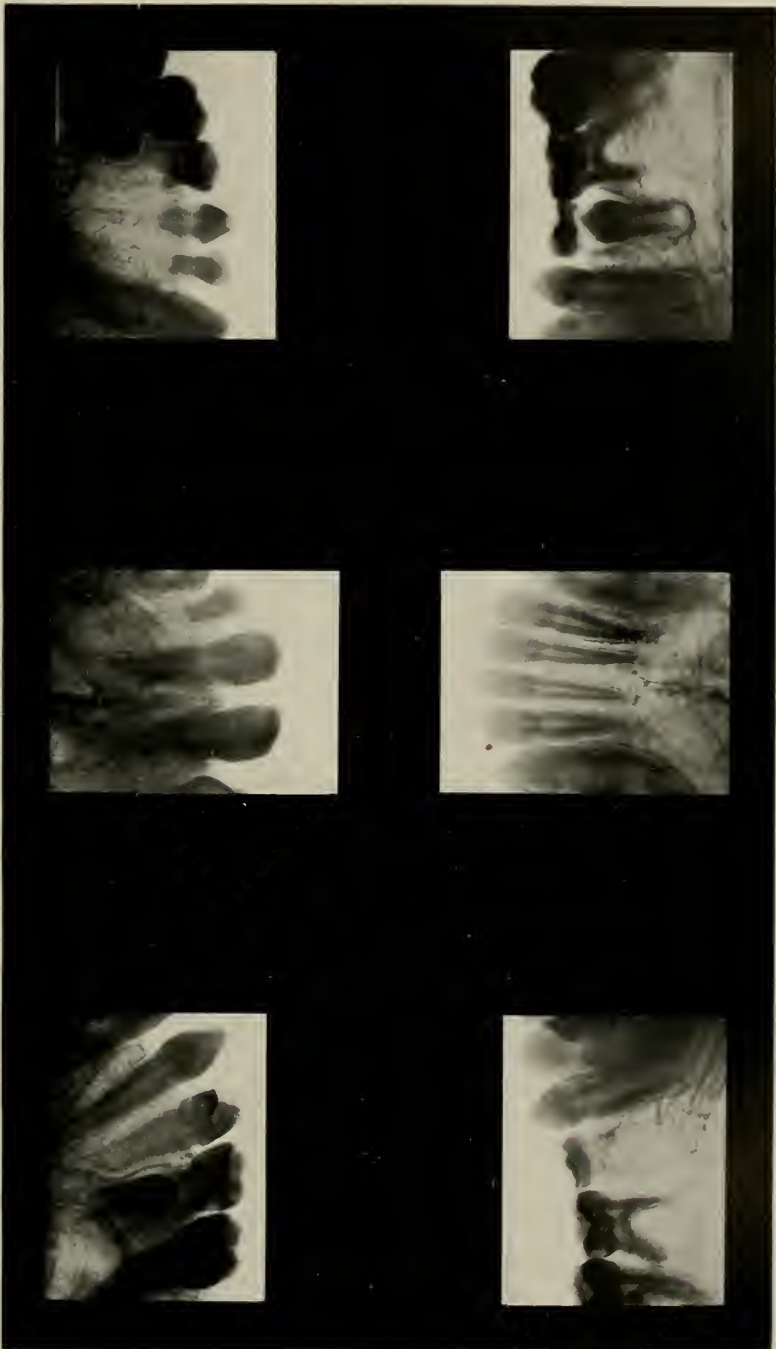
Radiographs demonstrating the congenital absence of seven secondary teeth. (Radiograph by Schamberg, of New York City. Case: One in the practice of Dr. Ottolengui, of New York City.)
